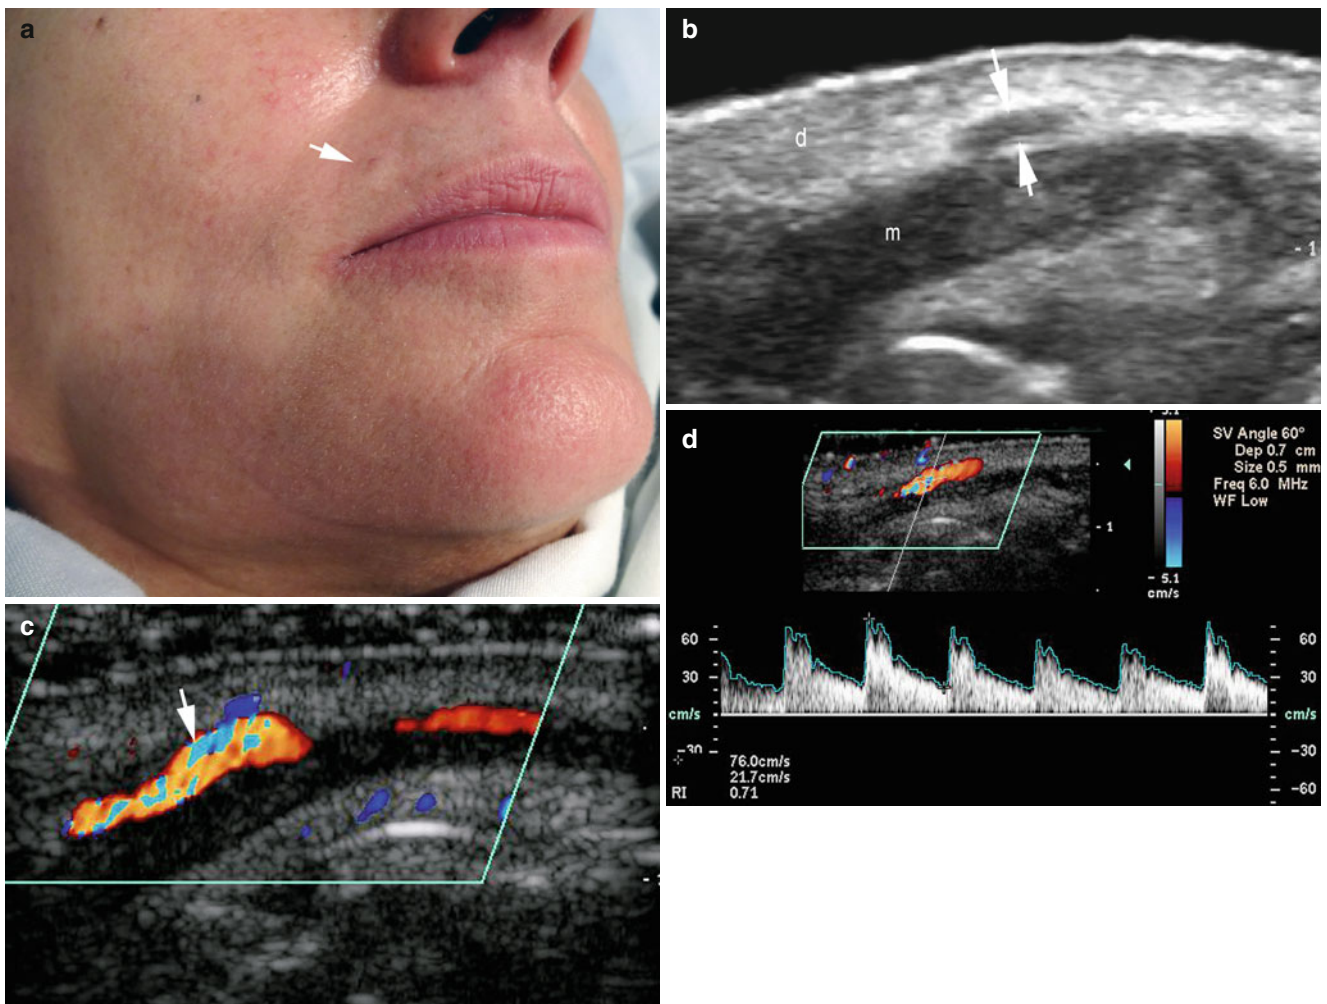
(a–d) Caliber persistent artery of the lip. (a) Clinical image shows a tiny erythematous lump in the right border of the upper lip. (b) Grey scale ultrasound image (transverse view) shows a prominent hypoechoic duct (arrows) in the dermis of the upper lip. (c) Color Doppler
